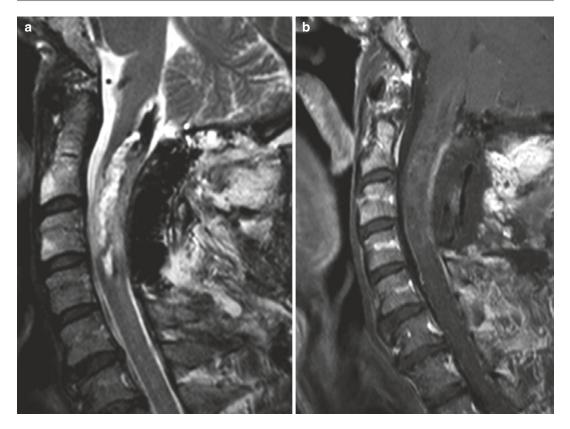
Postoperative MRI scan. The MRI scan shows postoperative sagittal T2 (a) and contrast T1 (b) rendering gros total resection of the ependymoma
